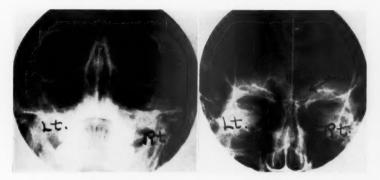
X-ray pictures demonstrating submucosal hematoma of floor of right frontal sinus (Case 1).
